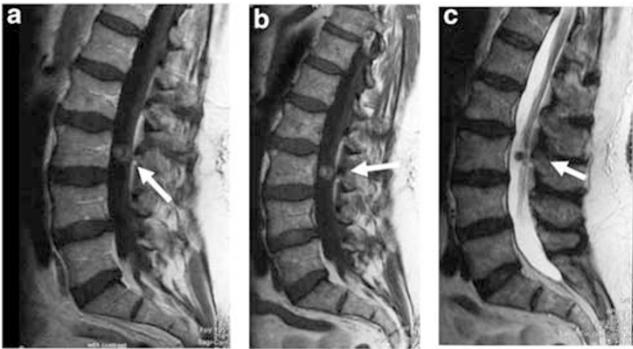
Lumbar MRI shows a nodular mass at the L3 level. The lesion is slightly hyperintense on T1-weighted images (a) without contrast enhancement (b) and hypointense on T2-weighted images (c)
